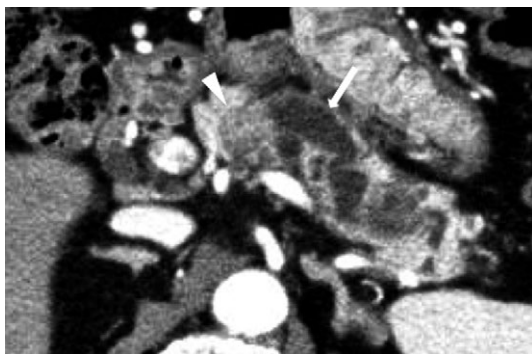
Enhanced CT images showing a weakly enhanced, ill-demarcated mass at the pancreatic body, 20×18 mm in size (arrow head), and a marked dilation of the upstream main pancreatic duct (arrow).
